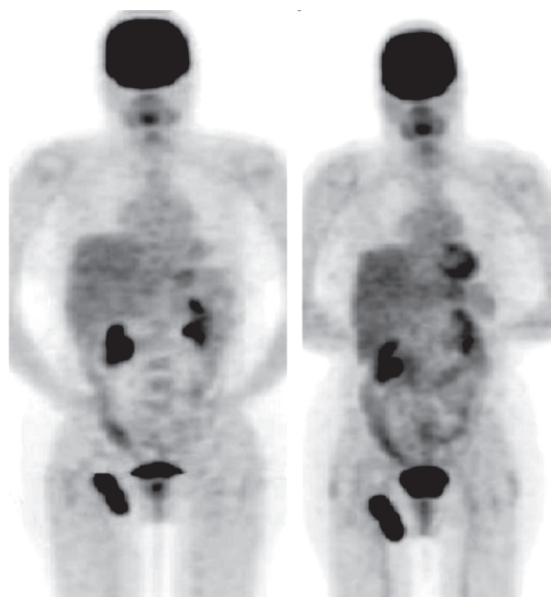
Patient (61 years, female), melanoma lower extremities (Breslow 2.1 mm, ulceration). Inguinal lymph nodes metastases with a SUVmax of 9.2 first scan and 10.5 second scan
